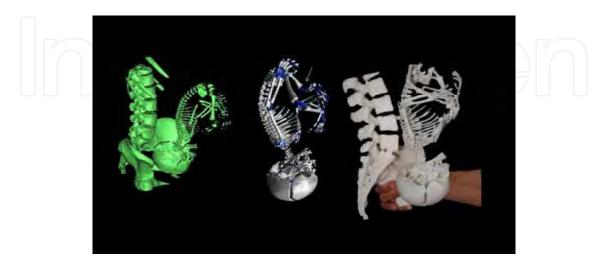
34 weeks, 3D virtual and physical models of the skeleton of the fetus built on SLA (3D systems - Viper Si) from CT scan.
